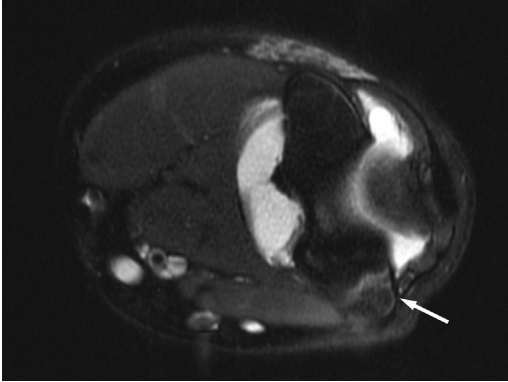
MRI axial T2 FAT SATURATED image of a 12-year-old girl who plays year-round softball demonstrating elbow medial epicondyle apophysitis. Note the edema within the epicondyle and bright signal at the apophysis (arrow). (Courtesy of San Diego Pediatric Orthopedics, San Diego, CA; with permission.)
